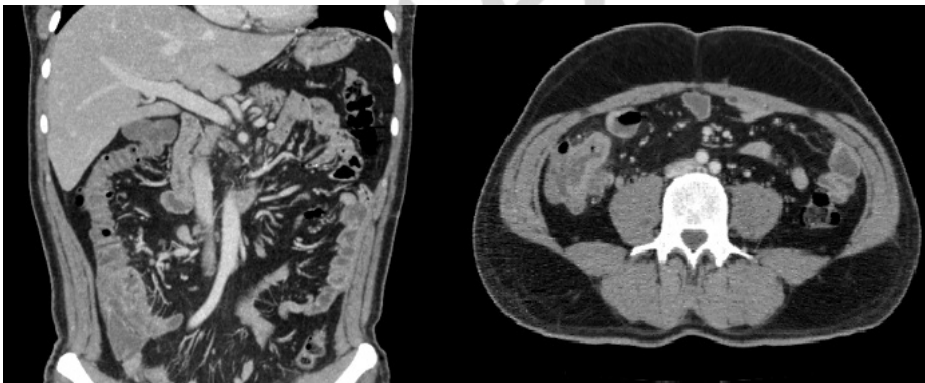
Abdominal CT showing a normal ileocecal appendix and a parietal thickening of the terminal ileum.
